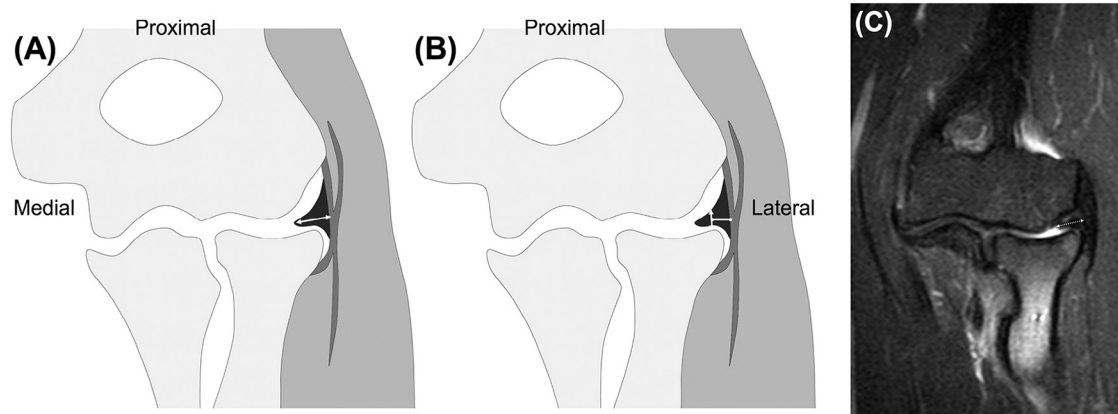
Measurement of length and thickness of plica based on coronal magnetic resonance imaging. (A) The mediolateral length of the plica (arrow) was measured. (B) The craniocaudal thickness was measured at a distance of 4 mm (arrow) from the capsule. (C) A prominent plica (arrow) was observed on a coronal T2 magnetic resonance image.
